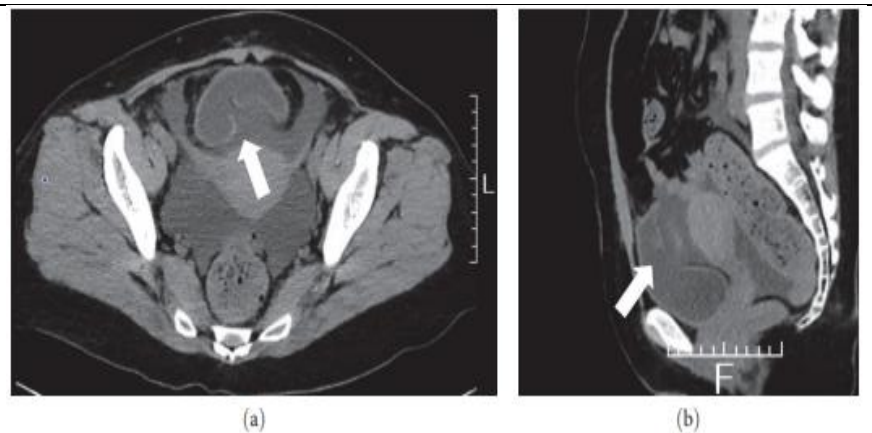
Computed tomography images of the bladder indicate a rupture from the posterior wall: (a) axial and (b) sagittal views. Arrows point to the ruptured wall.
